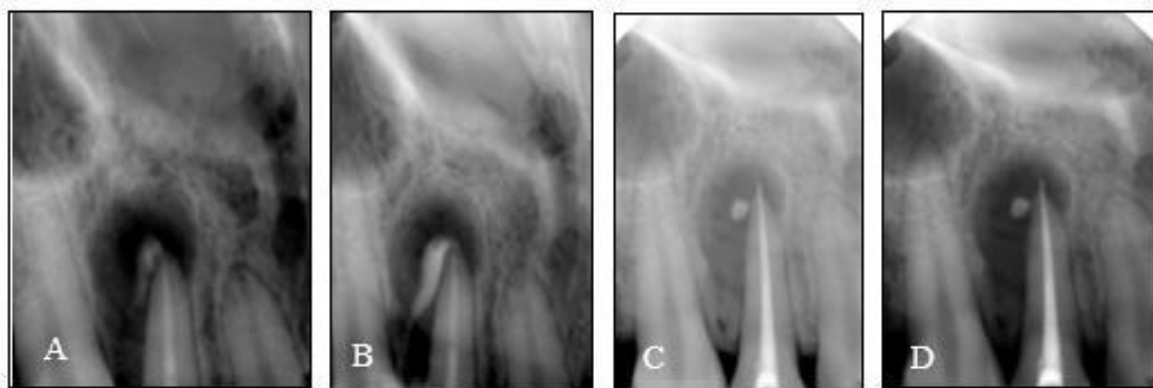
Radiographic View (A). CaOH Medicament, (B) Second CaOH Medicament (C) Post obturation root canal, (D) 3 months after post obturation
